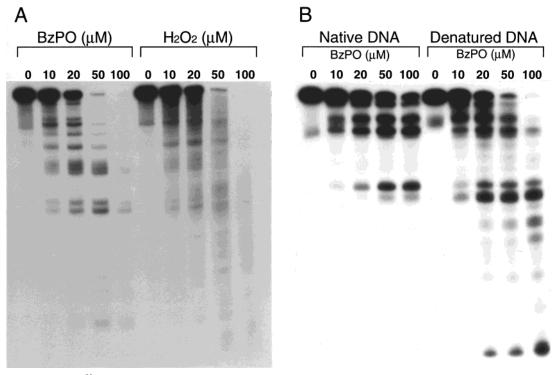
Autoradiogram of ^{32}P -labeled DNA fragments incubated with BzPO and H_2O_2 in the presence of Cu(I). (A) The reaction mixture contained the ^{32}P -5'-end-labeled 337-bp fragment (*Pst*I 2345-*Ava*I *2681), 10 μ M per base of sonicated calf thymus DNA, 15 μ M CuCl, and BzPO or H_2O_2 in 200 μ L of 10 mM phosphate buffer (pH 7.8) containing 2.5 μ M DTPA. After the incubation at 37 °C for 90 min, followed by piperidine treatment, the treated DNA fragments were electrophoresed on an 8% polyacrylamide/8 M urea gel (12 × 16 cm), and the autoradiogram was obtained by exposing X-ray film to the gel. (B) The reaction mixture contained the ^{32}P -5'-end-labeled 348-bp fragment (*Sty*I 13160-*Eco*RI *13507), 10 μ M per base of sonicated calf thymus DNA, BzPO, and 15 μ M CuCl in 200 μ L of 10 mM phosphate buffer (pH 7.8) containing 2.5 μ M DTPA. For DNA denaturation, DNA was treated at 90 °C for 5 min and quickly chilled before incubation at 37 °C for 60 min. The DNA fragments were treated with 1 M piperidine for 20 min at 90 °C and then electrophoresed on an 8% polyacrylamide/8 M urea gel. The autoradiogram was obtained by exposing X-ray film to the gel.
